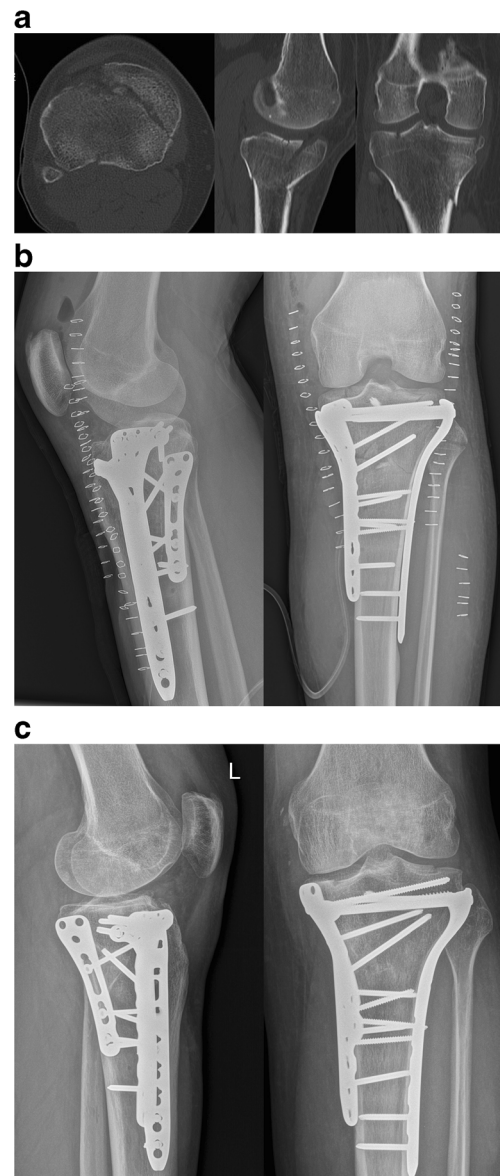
Demonstrative case with moderate functional outcome. a Pre-operative CT-images showing a three-column tibial plateau fracture. b Post-operative coronal and sagittal X-rays after combined lateral, anteromedial and posteromedial plating. c Coronal and sagittal X-rays at 1 year follow-up
